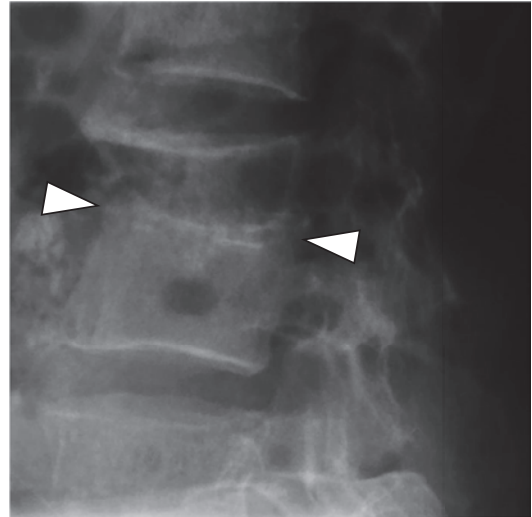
Treated tuberculous spondylodiscitis. 2-year follow-up lateral radiograph shows complete vertebral fusion of two adjacent vertebral bodies (arrowheads)
